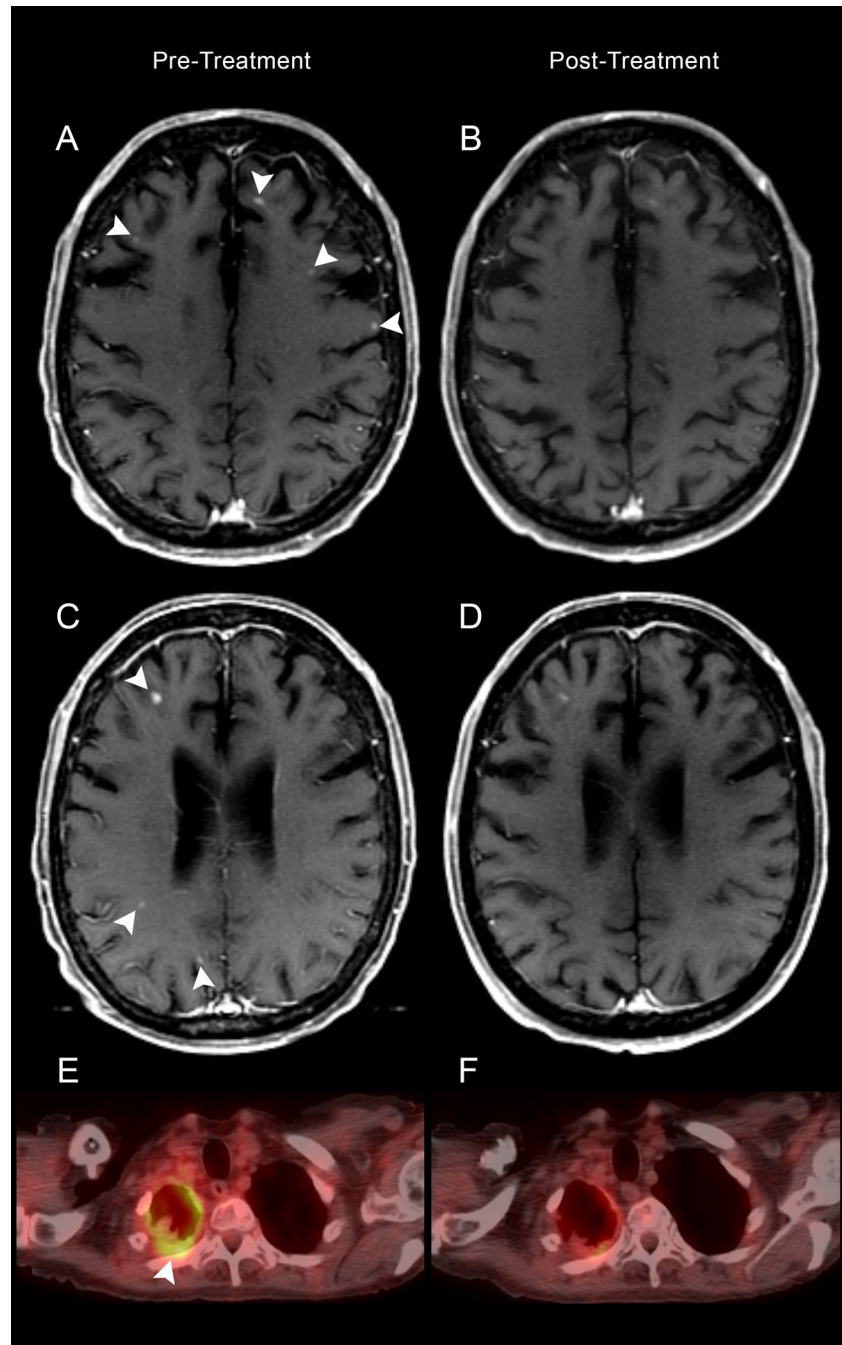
A–E: Pretreatment MR (A, and C) demonstrates enhancing lesions (arrowheads) on the axial T1-weighted images, decreased in number and size following treatment (B and D). FDG-PET CT reveals pleural hypermetabolism in the right hemithorax (E) with decreased avidity post-therapy (F).
